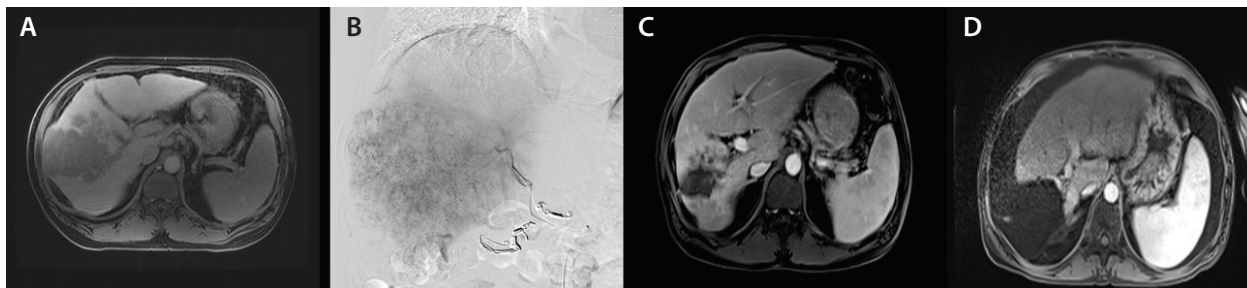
Right liver hepatoma successfully downstaged with Y-90 SIRT and treated with curative resection. An MRI showing a large, right liver HCC (A), which was initially treated with right lobar radioembolization (B). Contrast-enhanced MRI after Y-90 demonstrating interval decrease in tumor size with contralateral hypertrophy (C). Contrast-enhanced MRI following successful resection of the downstaged liver mass with no evidence of recurrent disease (D).
